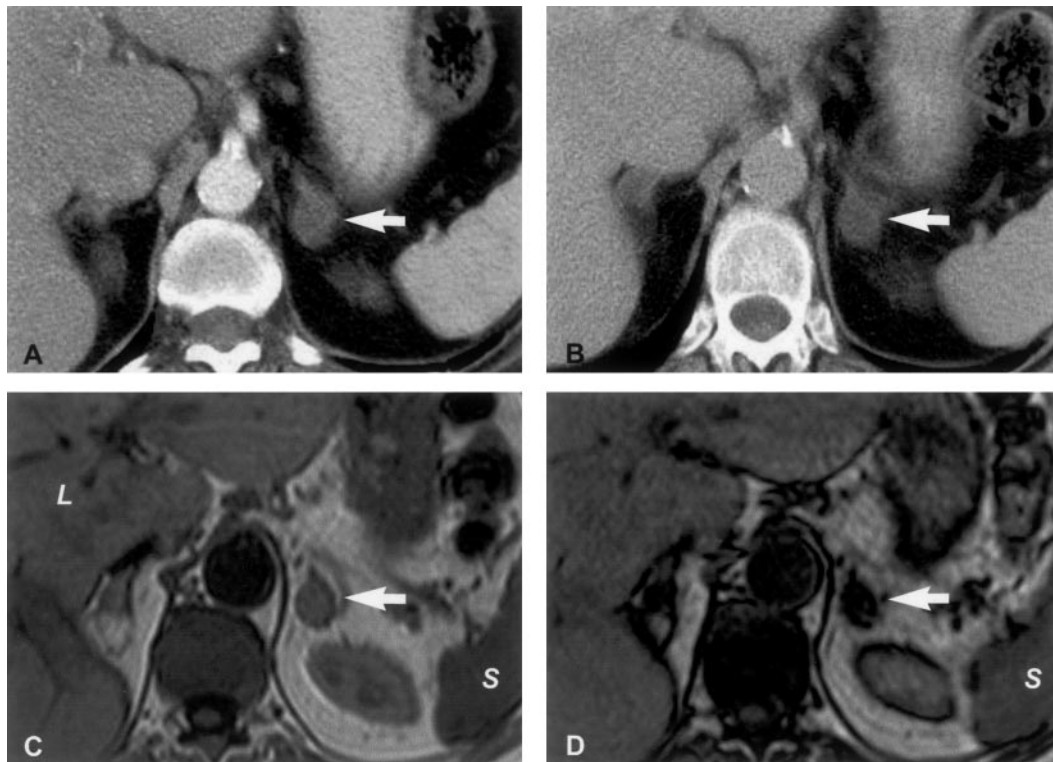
Radiological panel of an adrenal cortical adenoma. Findings in a 66-yr-old woman with a history of breast cancer. Panels A and B demonstrate the use of CT for calculation of the relative enhancement washout. A, The contrast-enhanced CT shows a left-sided 1.5-cm adrenal mass (arrow) with a mean attenuation of 32.9 HU. B, On the 12-min delayed image, the attenuation of the left adrenal (arrow) is 12.9 HU. The relative enhancement washout is calculated using the following equation: percentage of relative enhancement washout =  $(1 - \text{delayed enhanced HU value}/\text{initial enhanced HU value}) \times 100$ . With a relative washout of  $(1 - 12.9/32.9) \times 100 = 61\%$ , the delayed enhanced CT is indicative of an adrenal adenoma (196, 215). Panels C and D depict the decrease in signal intensity in adrenal cortical adenoma using chemical-shift MRI. C, In the T1-weighted in-phase image, the signal intensity (SI) of the adrenal mass (arrow, SI = 131) is relatively isointense to the liver (L) and of slightly higher intensity than the spleen (S; SI = 93). D, The T1-weighted opposed-phase MRI shows a signal drop in the adrenal mass (arrow, SI = 39) relative to the spleen (S; SI = 110). The adrenal-spleen-ratio (ASR) is calculated by the following formula (Refs. 238 and 239):  $\text{ASR} = [(\text{SI adrenal mass}/\text{SI spleen})_{\text{opposed-phase}}/(\text{SI adrenal mass}/\text{SI spleen})_{\text{in-phase}}] \times 100$ . The diagnosis of an adenoma is confirmed by an ASR of  $[(39/110)/(131/93)] \times 100 = 25.2$ .
